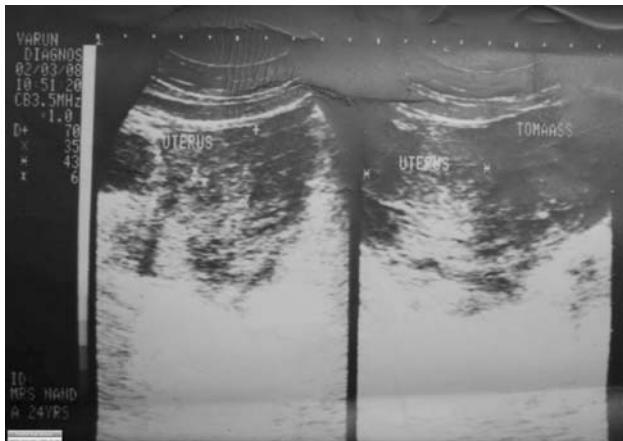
Ultrasonography showing tubo-ovarian mass
